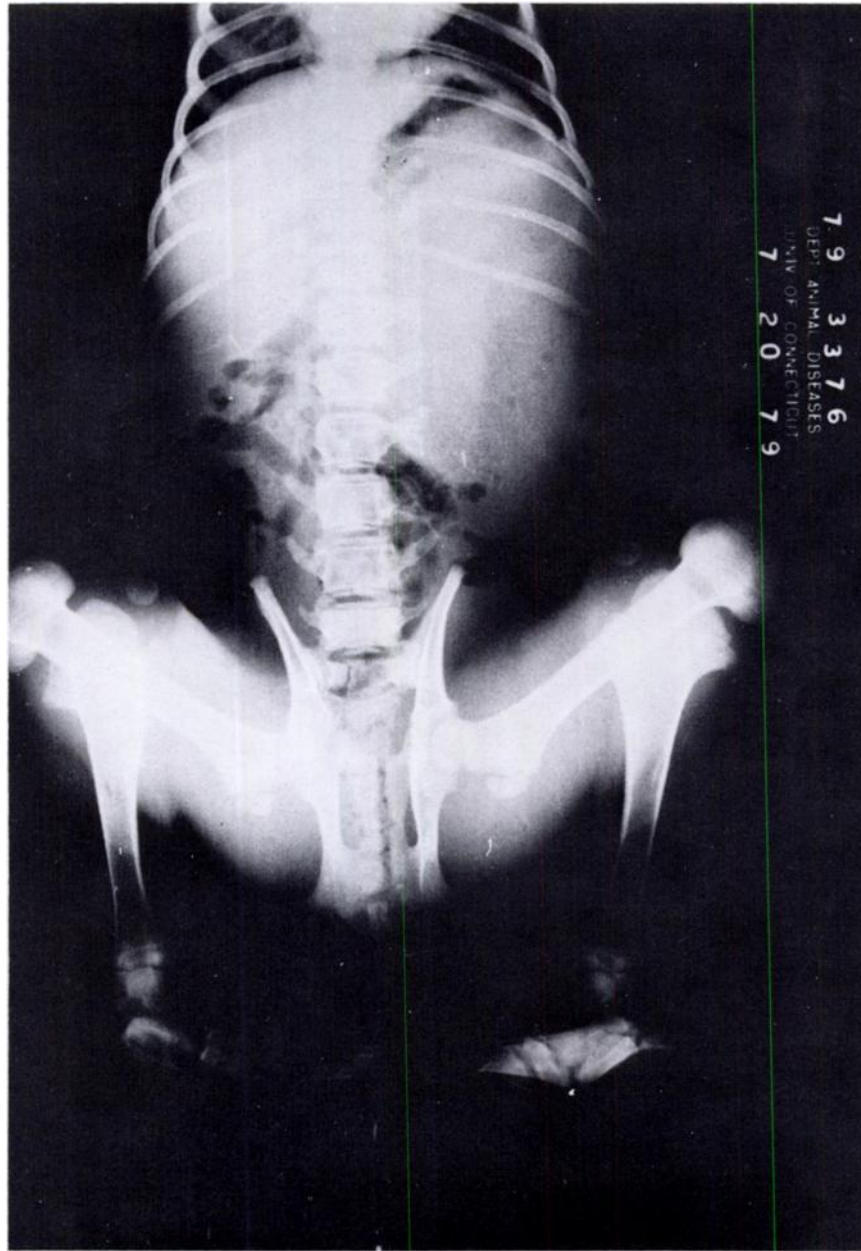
The ventrodorsal radiograph of the unreduced rear legs demonstrated bilateral medial patellar luxation, remodeling of the stifle, medial rotation of the tibias, and a normal pelvis.
